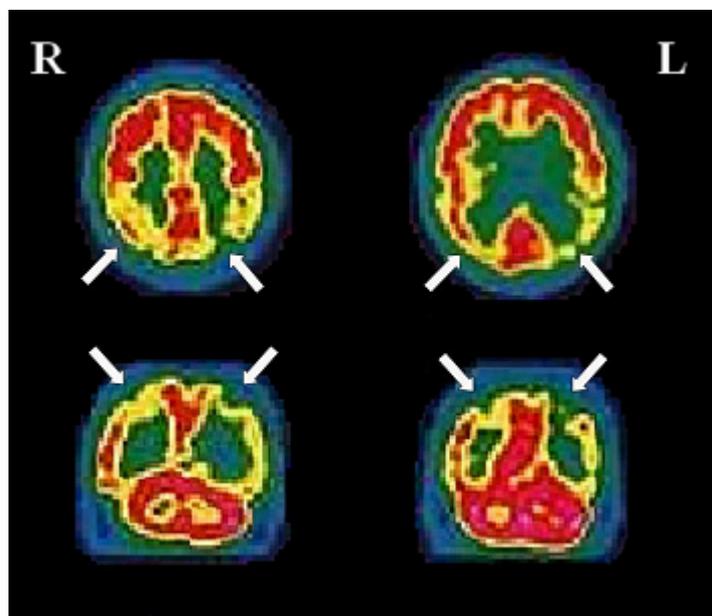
Cerebral perfusion tomoscintigraphy - arrows indicate parietal hypoperfusion, more pronounced in the left hemisphere.
